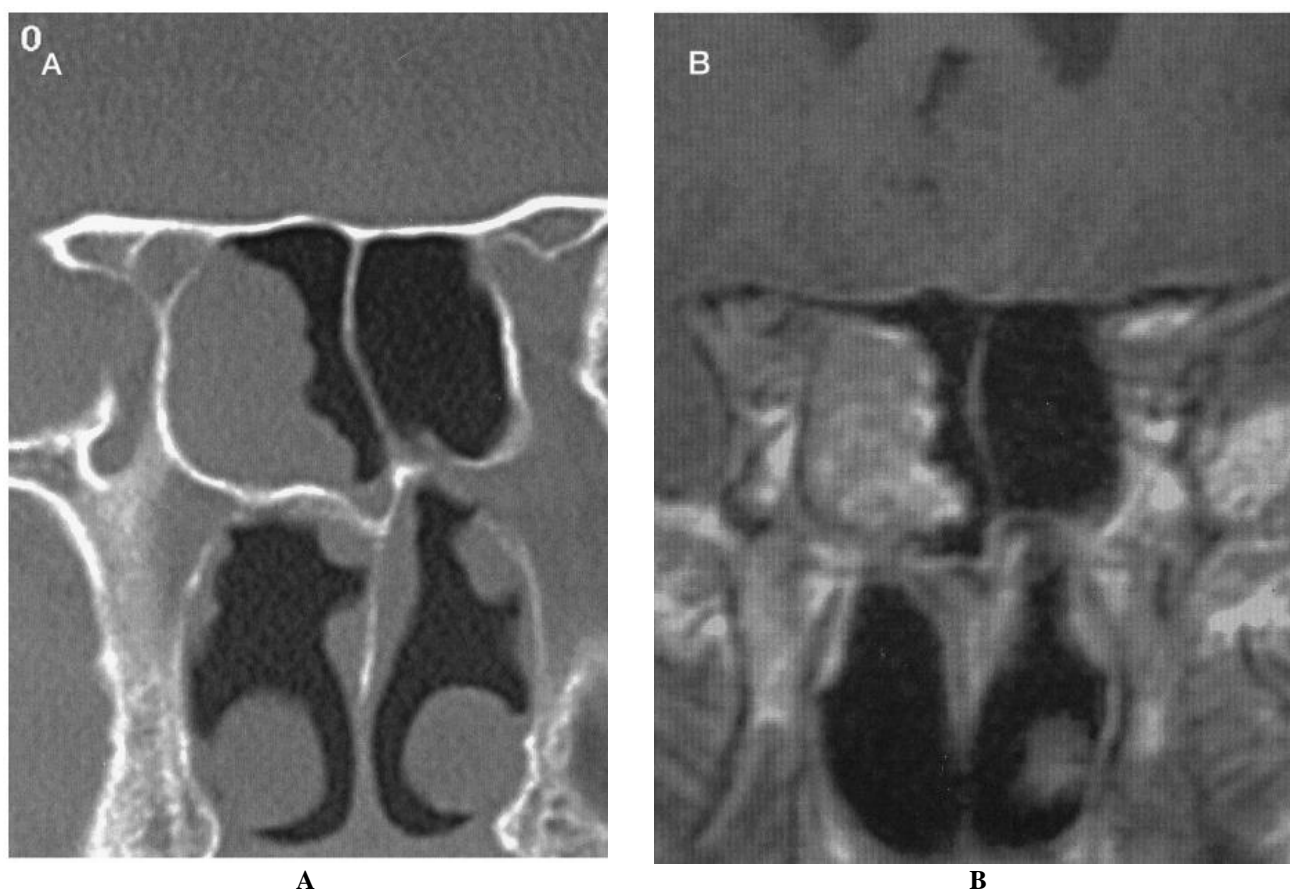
(A) Coronal computed tomography image at initial presentation of case 1 revealed a density within the right-side sphenoid sinus. (B) Coronal T1-weighted magnetic resonance imaging scan through a similar section after gadolinium demonstrates heterogeneous enhancement of the sphenoid sinus mass
